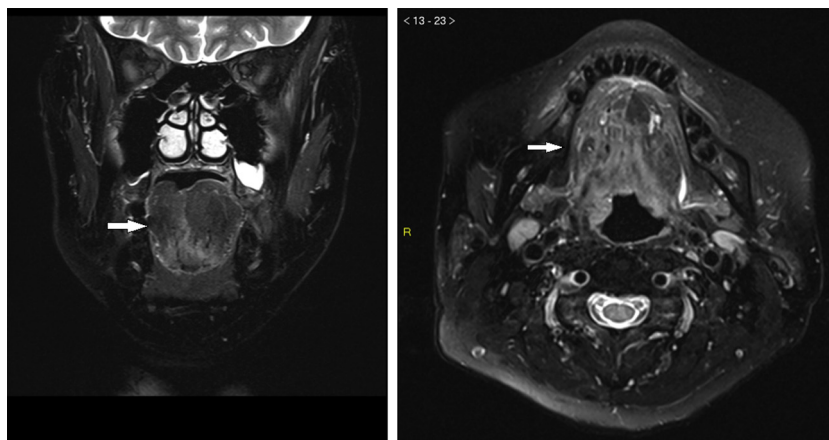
T2W MRI with fat saturation in Coronal and Axial view depicting wasting of the right hemitongue.
